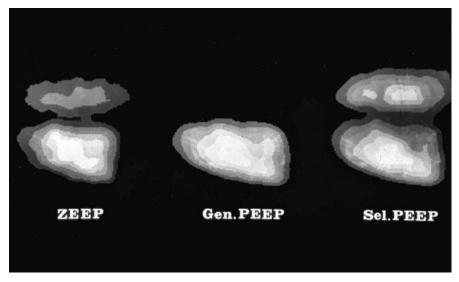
Perfusion scintigrams of an anaesthetised subject in the lateral position. Note the perfusion in the upper lung during mechanical ventilation without end-expiratory pressure (ZEEP), the almost complete elimination of blood flow through the upper, nondependent lung during ventilation with PEEP of 10 cmH₂O to both lungs (*Gen.PEEP*). Finally, a selective PEEP of 10 cmH₂O was applied solely to the dependent lung and both lungs were ventilated with a similar tidal volume via double-lumen endobronchial catheter (*Sel.PEEP*). This resulted in a more even distribution of perfusion between the two lungs. (From [14], with permission from the publisher)
